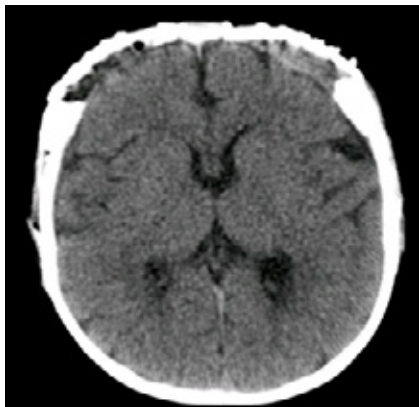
Non-contrast CT at 4 weeks after CVR with CSF leak, no evidence of hydrocephalus. The ventricle slightly smaller compared to preoperative head CT
